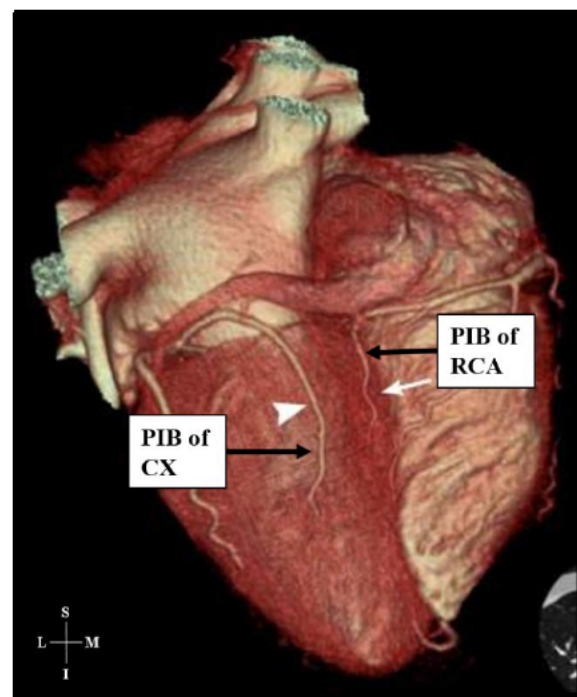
Volume rendered CT image of posterior view of heart demonstrating co-dominance (Adapted from Lin *et al.*, 2015)
